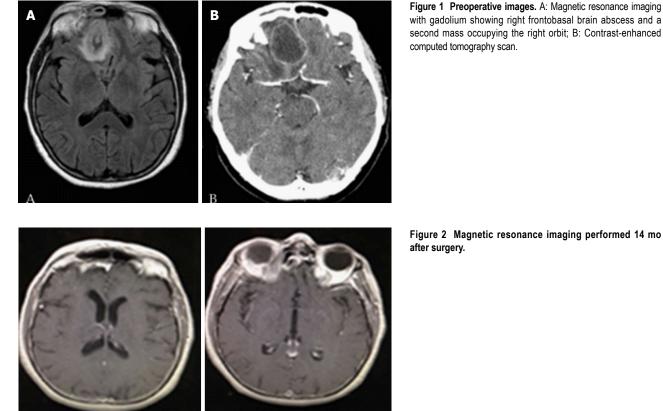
Magnetic resonance imaging performed 14 mo
